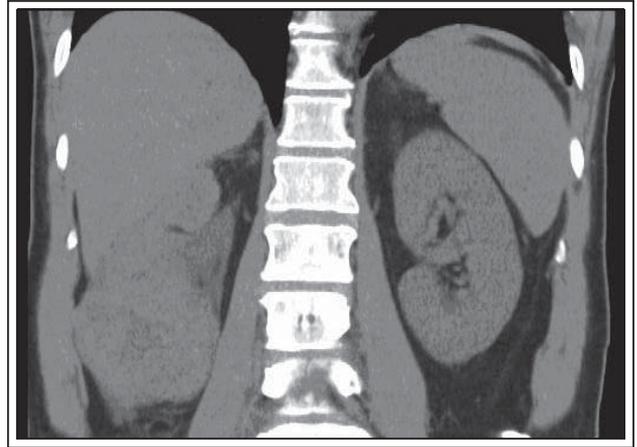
CT scan showing a heterogenous right kidney mass.
